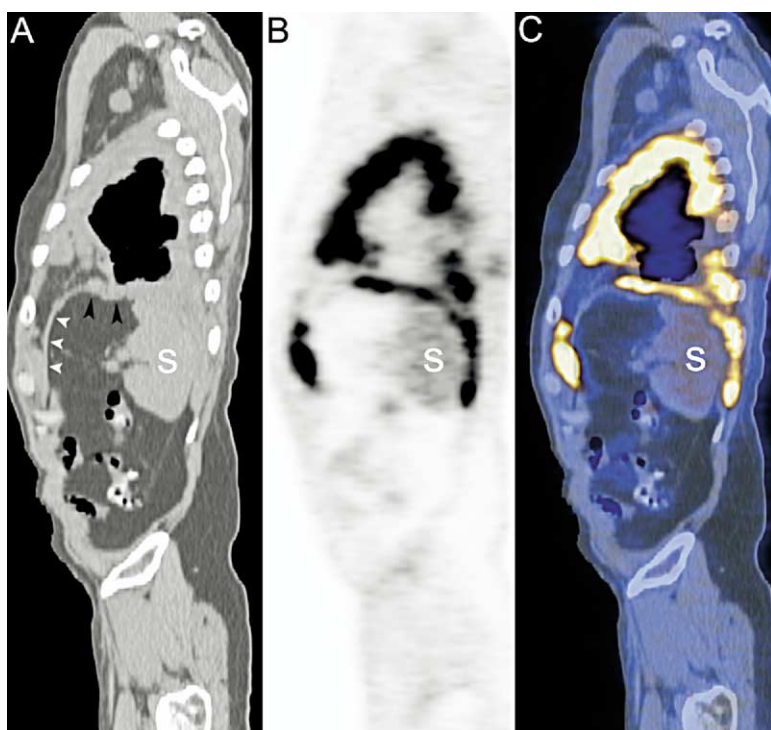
Sagittal CT (A), PET (B), and integrated CT-PET (C) show diffuse uptake of FDG in malignant pleural mesothelioma (MPM). Multiplanar reconstruction is useful in evaluating diaphragm and shows normal diaphragmatic contour (*white arrow-heads*) and focal lobular irregularity (*black arrow-heads*) suspicious for transdiaphragmatic extension of tumor. Laparoscopic biopsy confirmed T4 disease. S, Spleen.
